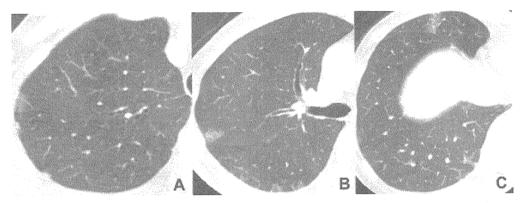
HRCT image showing random GGA pattern in a 56-year-old woman positive for anti-CADM-140. Small, peripheral, localized GGAs were distributed in a patchy manner, with no consolidation. The patient remained alive 4 years after diagnosis.
